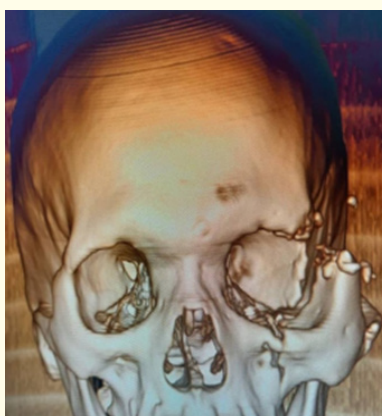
Computed tomography of a patient with a fracture of the malar bone. Courtesy of Dr. Carlos Juan Puig González.
